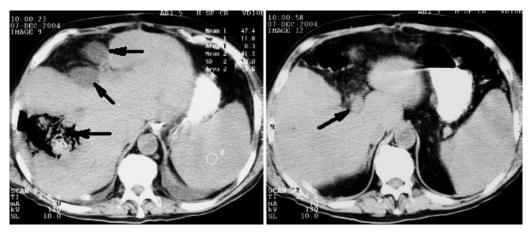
Computed tomography of a patient after simultaneously performed bowel and liver resection plus RFA. Hepatic abscesses occurred at resection- and RFA sites (arrows).
